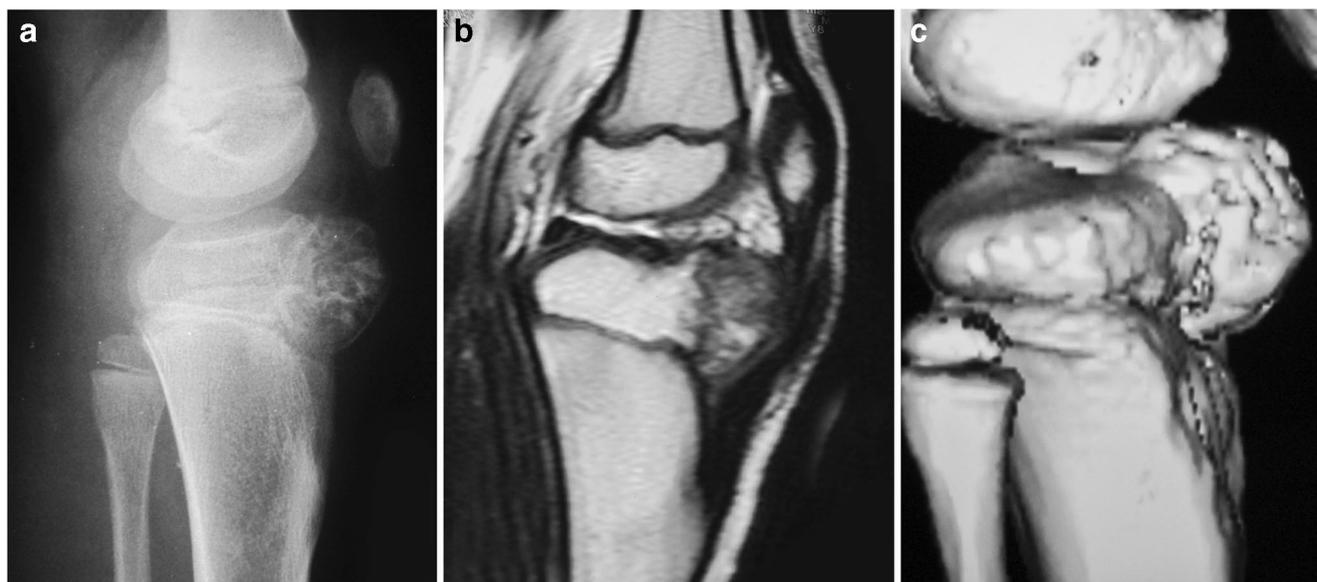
Dysplasia epiphysealis hemimelica mimicking Osgood-Schlatter’s disease in an 8-year-old female. a Lateral radiograph of the lesion showing an irregular ossification and enlargement of the proximal tibia. b
